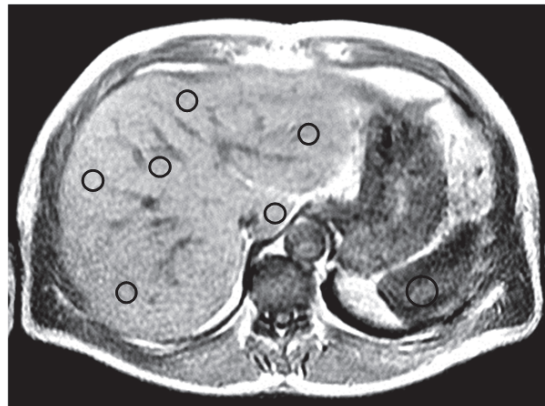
Localization of the liver fat ROIs in the MR image.
